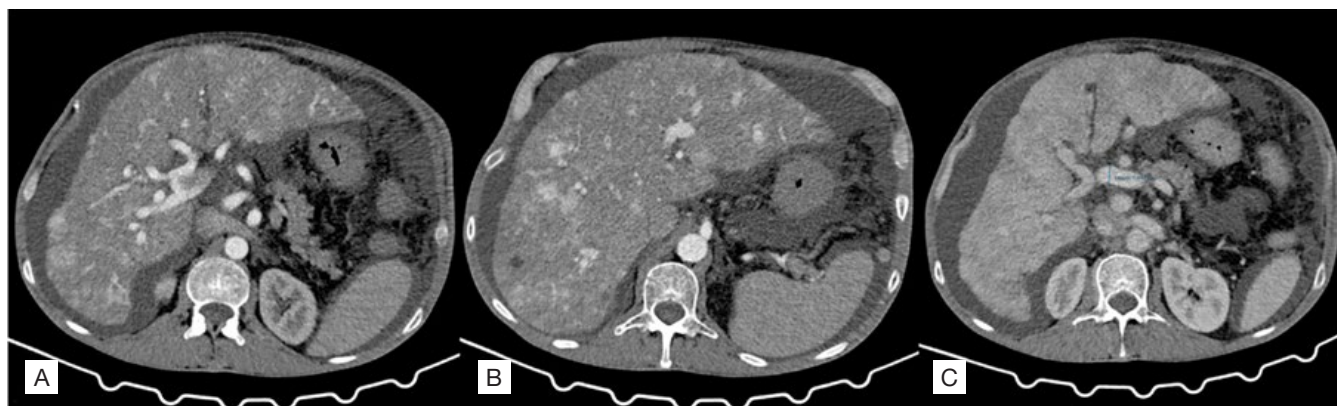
Contrast-enhanced triphasic abdominal computed tomography demonstrating hepatic vascular malformations in hereditary haemorrhagic telangiectasia. [A, B] Arterial phase images show marked enlargement of the hepatic arterial branches with extensive arterioportal shunting, resulting in early and heterogeneous hepatic parenchymal enhancement. Multiple intrahepatic vascular malformations are identified, with abnormal early opacification of portal venous branches. [C] Late venous phase image demonstrates persistent heterogeneous enhancement consistent with complex intrahepatic vascular malformations, including communications between the hepatic artery and hepatic veins, as well as dilation of the portal vein trunk, explaining the coexistence of portal hypertension and high-output cardiac failure.
